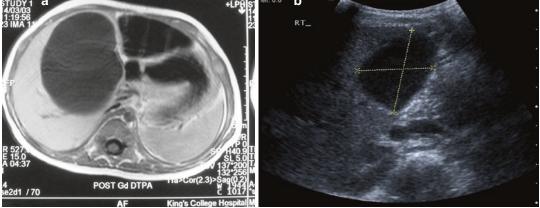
Antenatally detected parenchymal liver cyst: measured at 22 mm diameter during CT scan in first week of life (a) and reaching 40×50 mm by ultrasound at 9 years (b)
